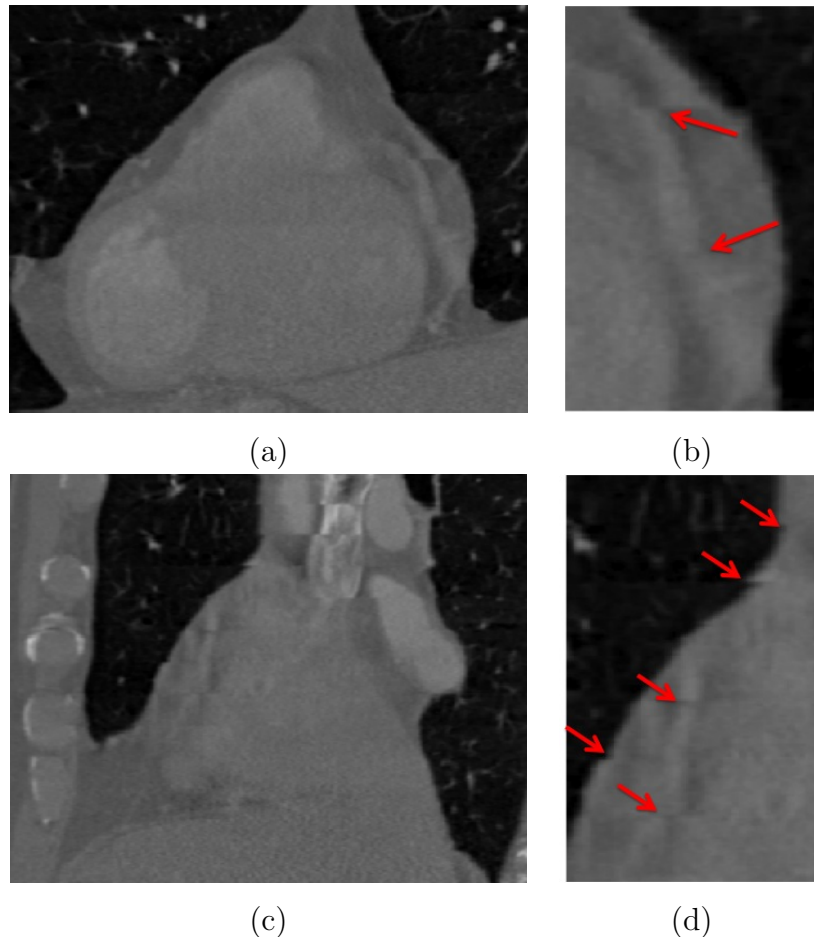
CTA images with stair-step artefacts. (a) and (c): Two slices of a CTA dataset showing the coronary artery in regions with stair-step artefacts highlighted in (b) and (d) respectively. The red arrows point to the location where stair-step artefacts occur.
